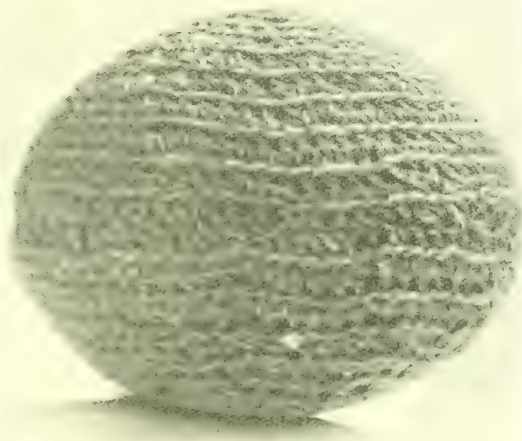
Compressor pad for use in X-ray examination of renal region.
